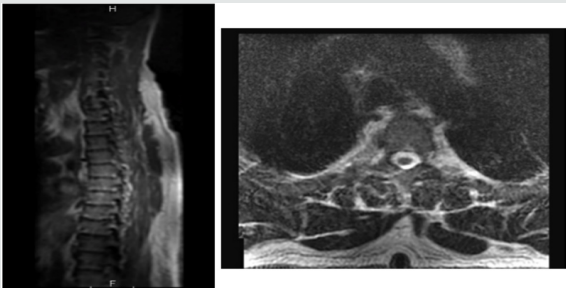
MRI Thoracic & Lumbar with IV contrast.
